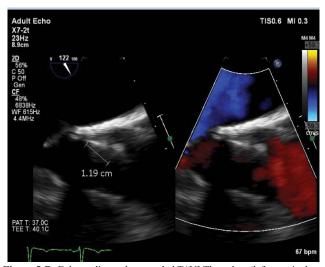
Echocardiography revealed TAVI Thrombus (left ventricular side).
